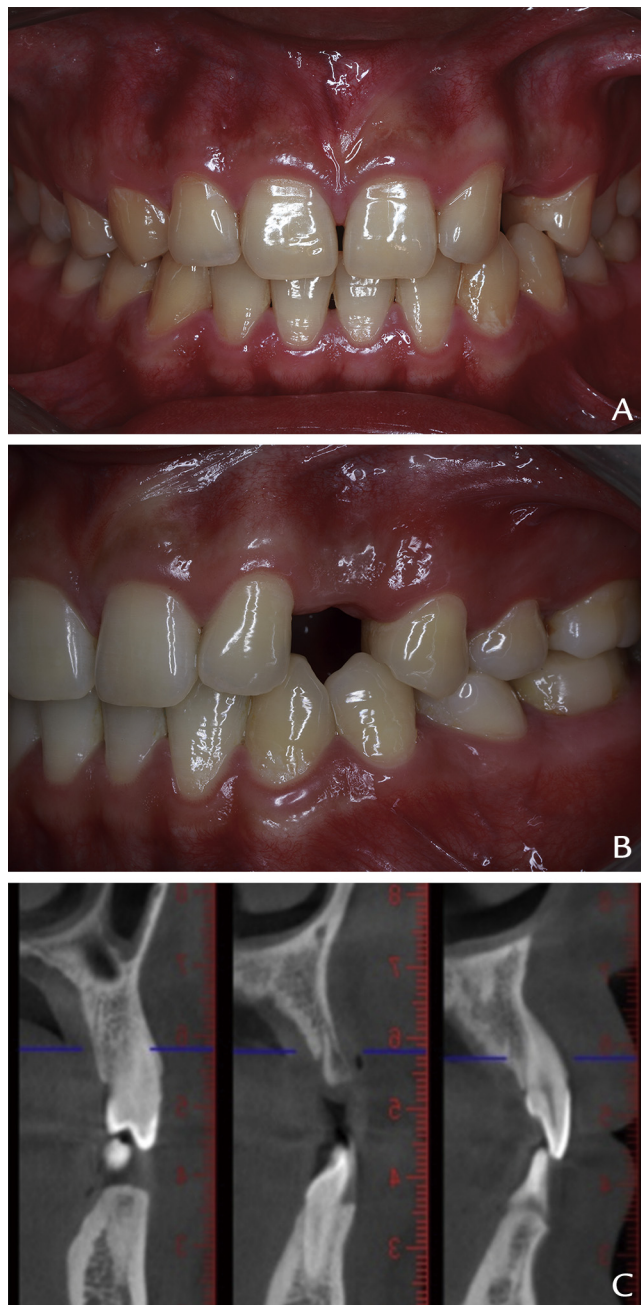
Pretreatment examination. A, Frontal view. B, Lateral view. C, Severe horizontal bone defect revealed on cone beam computed tomography.
